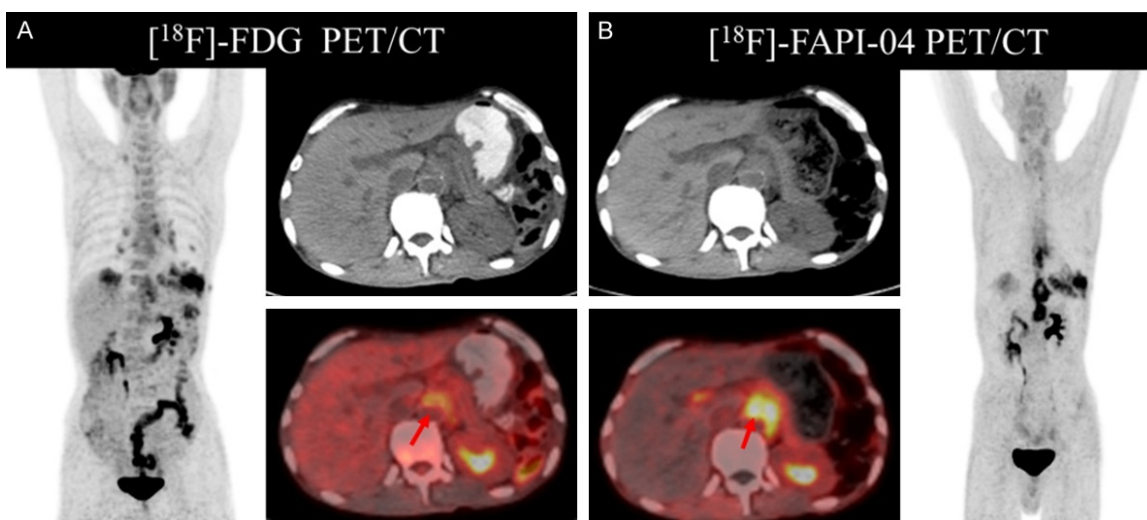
Detection results of lymph node metastasis. A 59-year-old man who had a one-month history of food choking, with a history of for cardia esophagus cancer surgery two years ago, without radiotherapy. Gastroscopy revealed inflammatory changes around the anastomosis. [¹⁸F]-FDG PET/CT images revealed hyperintensity mass around the anastomotic stoma of the esophageal operation area to the posterior pancreatic para-aortic area, fused into a mass (SUVmax: 3.8). [¹⁸F]-FAPI-04 PET/CT showed a clearer border of the mass extension (SUVmax: 8.72) compared to [¹⁸F]-FDG PET/CT, considering lymph node metastases. FAPI imaging uptake was significantly higher than FDG imaging in terms of the number of lymph node metastases and SUV uptake values.
